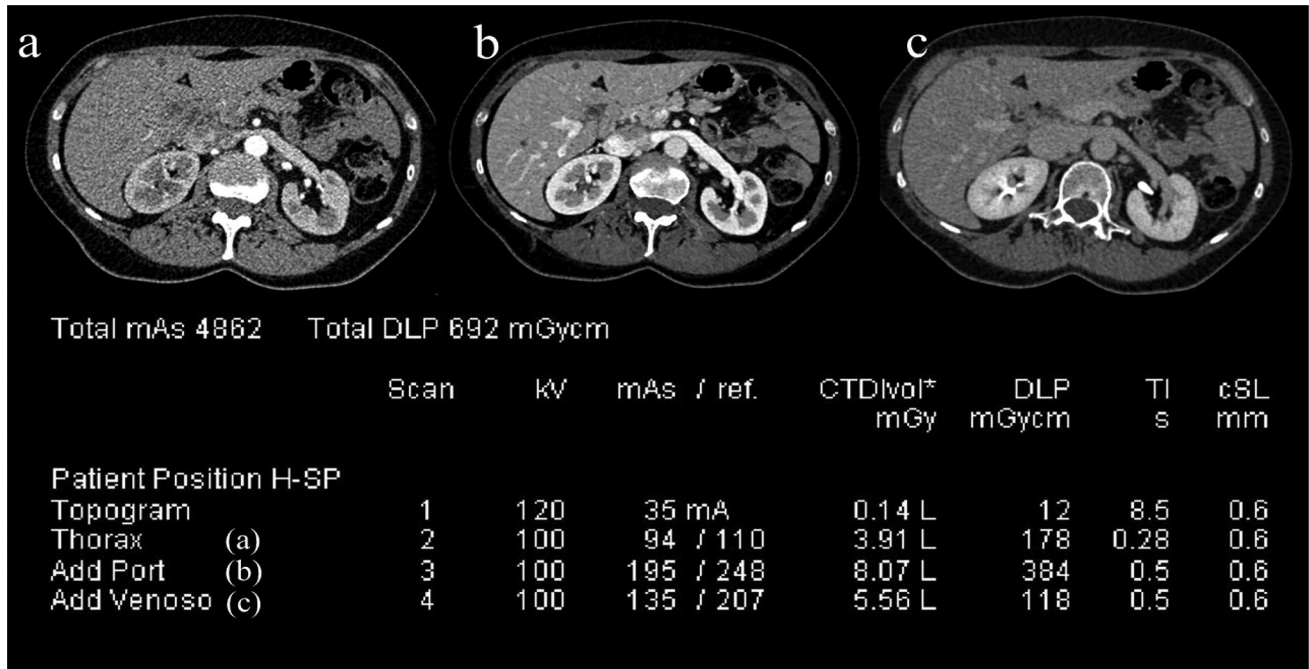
Female, 56 years old (56 kgs). Triple-phase (a, b, c) liver CT examination in the same patient 12 months later with the same equipment (Siemens Somatom Definition Flash) but different technical settings due to CT protocols optimization. If compared to the previous exam the TCM values are lowered in all protocols (see ref mAs and CTDI_{vol} compared to those of Fig. 1), especially in equilibrium-phase (c) where the late contrast-enhancement of liver lesions is evaluated and an increased image noise is acceptable. Note that the total DLP is halved if compared to Fig. 1 (total DLP is 692 mGycm vs 1235 mGycm)
